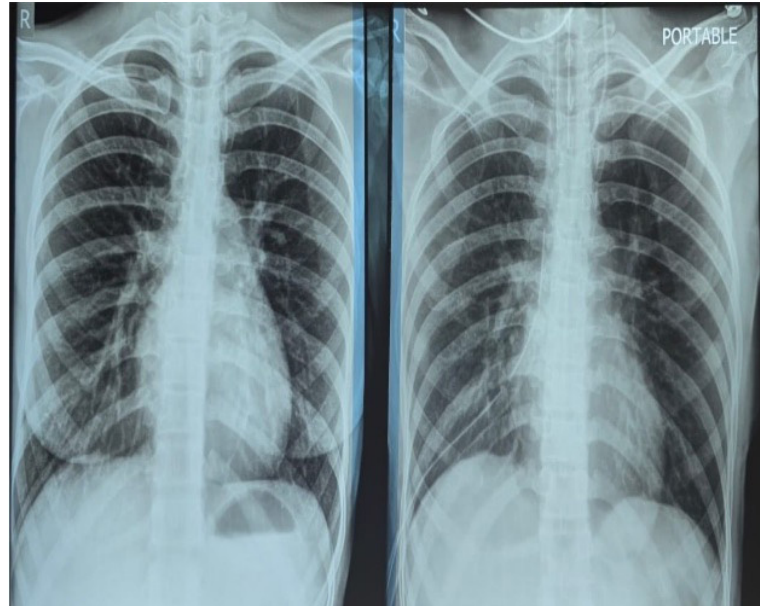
Presurgical and immediate post operative chest X-Ray
